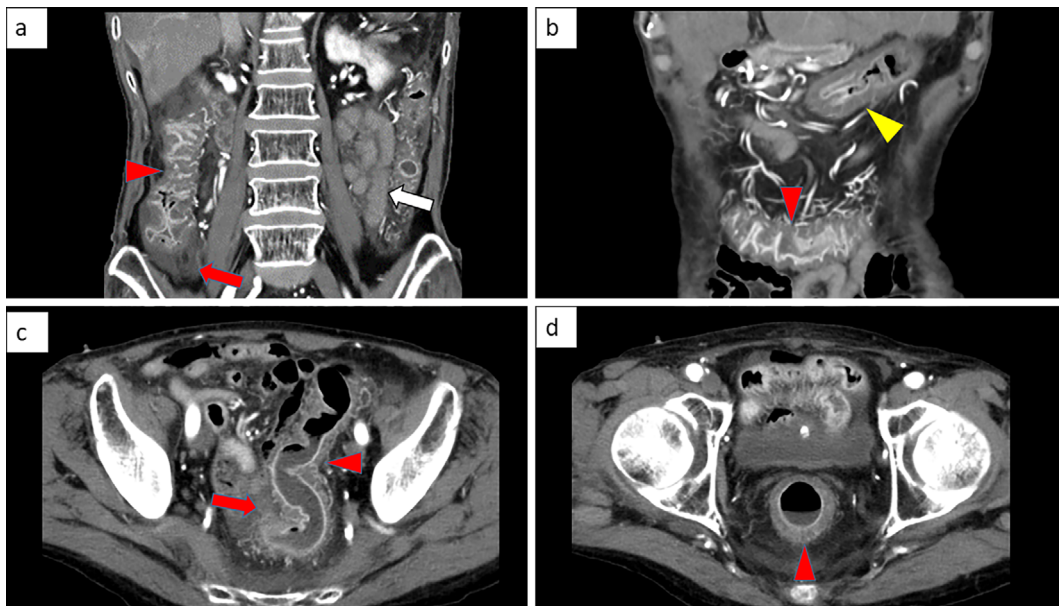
CECT showing significant bowel wall thickening between the cecum and the rectum (red arrowhead) without contrast failure or vascular thrombosis and also showing gastric wall thickening (yellow arrowhead). The small bowel wall did not show thickening (white arrowhead). Fat stranding is observed around the cecum and the sigmoid colon (red arrow). CECT: contrast-enhanced computed tomography
